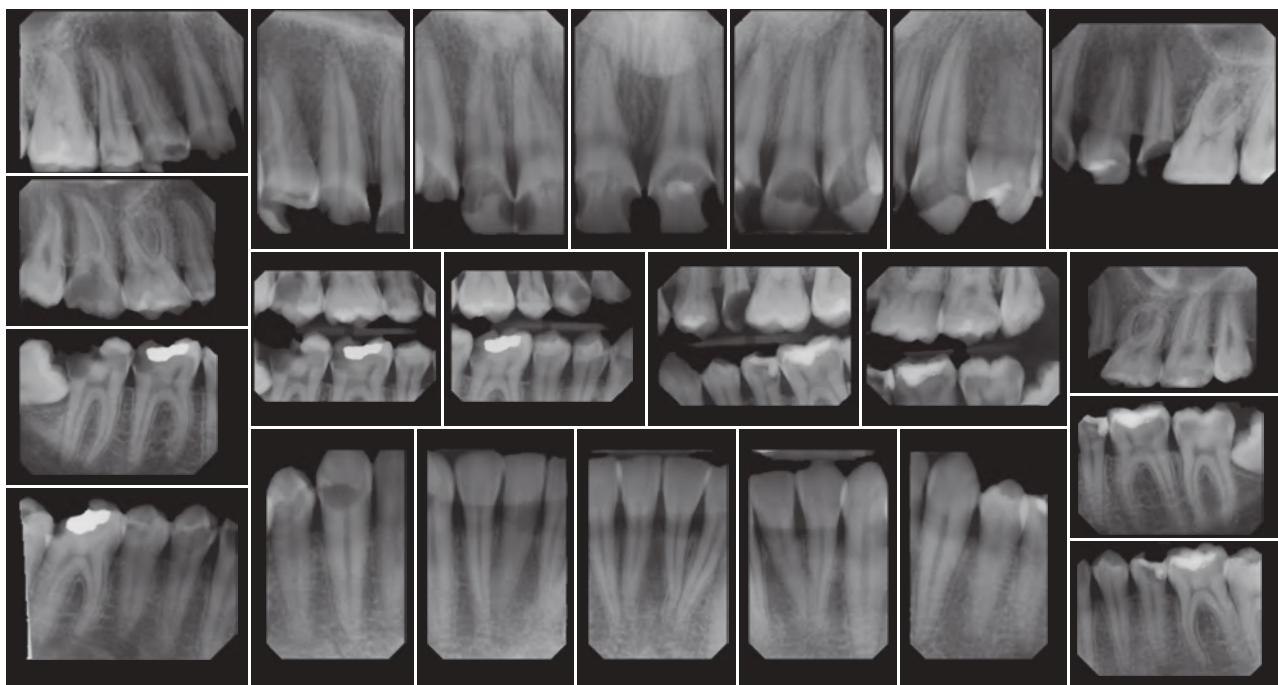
A 22-image complete mouth survey (CMS) consisting of 18 periapical and 4 bite-wing radiographs. The patient exhibits radiographic signs of rampant dental caries, impacted mandibular third molars, and erosion of the maxillary anterior teeth. (Courtesy Dr. Erika Benavides.)
